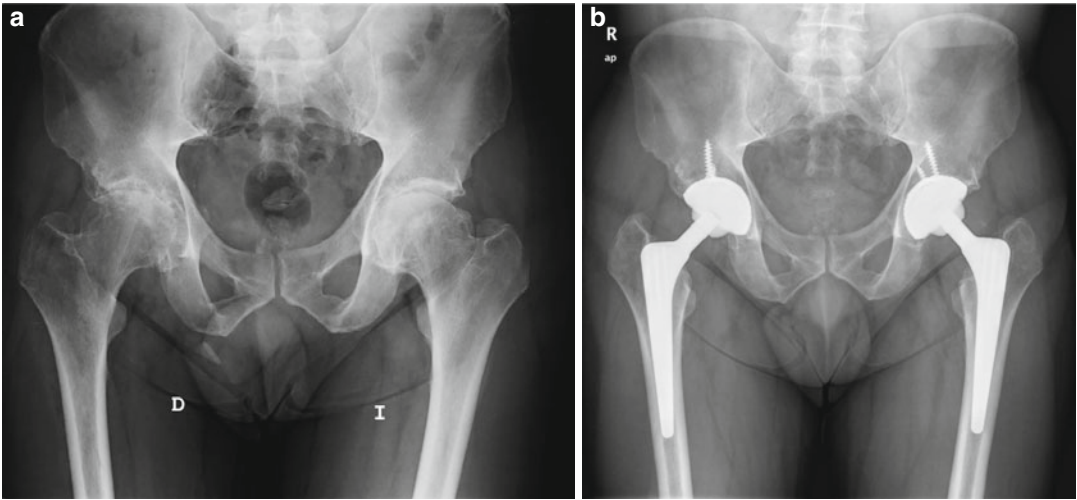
(a) Anteroposterior pelvic radiograph of a 56-year-old male patient showing hemophilic arthropathy of both hips. Note deformity in both femoral heads, osteopenic acetabulum, and dysplastic cylindrical femur. (b) Anteroposterior pelvic radiograph during the third
